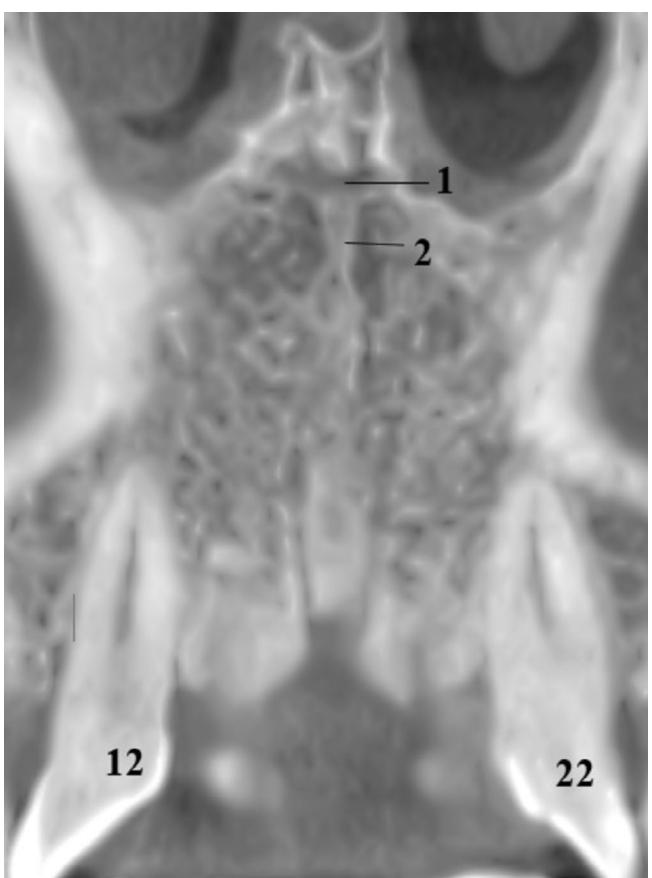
A 33-year-old male patient. CBCT, coronal scan, showing communication of left and right canalis sinuosus (1), which passes through the intermaxillary suture (2).
